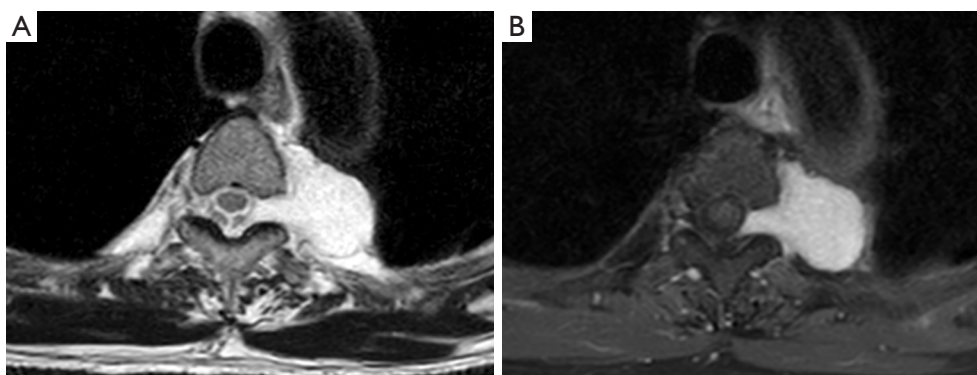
Magnetic resonance imaging shows a posterior mediastinal tumor extending into the intervertebral foramen. (A) T2-weighted image; (B) Gadolinium-enhanced T1-weighted image.
